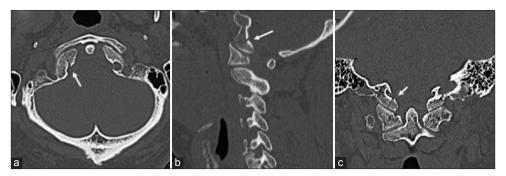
Axial (a), reconstructed sagittal (b), and coronal (c) computed tomography images at presentation. Note the comminuted fracture of the right occipital condyle (arrow) without displacement of the fracture fragments.
